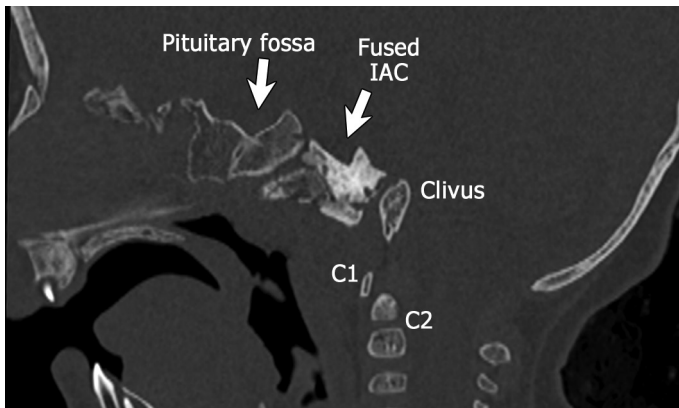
Midsagittal reformatted image of the temporal CT. Fused internal acoustic canal (IAC), atypical triangle-like pituitary fossa, upright clivus causing basilar kyphosis, and the relationship of the clivus with the upper cervical vertebrae are observed.
